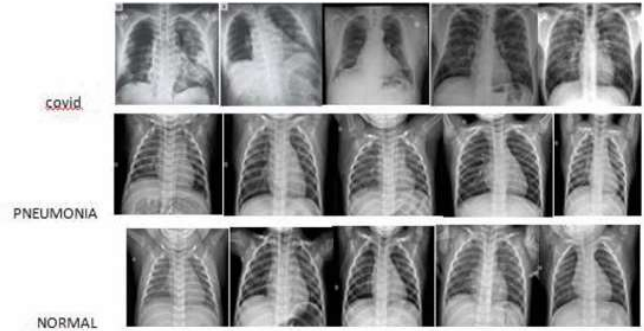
Chest X-ray image datasets
